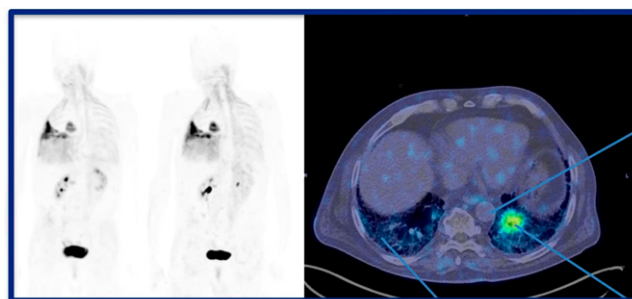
FAP-specific PET/CT in pulmonary fibrosis with lung cancer. Left: Tracer uptake in a patient with idiopathic lung fibrosis at 10 and 60 min after injection. Right: PET/CT of pulmonary fibrosis, used to generate dynamic curves for perfusion, fibrosis, and tumor. The perfusion curve (not pictured) showed the classic washout of a small molecule. Fibrosis rapidly plateaued and then slowly declined. Tumor uptake, however, showed a gradual progressive increase and then gradual decline, clearly indicating a potential kinetic difference between benign fibrotic conditions and cancer.
